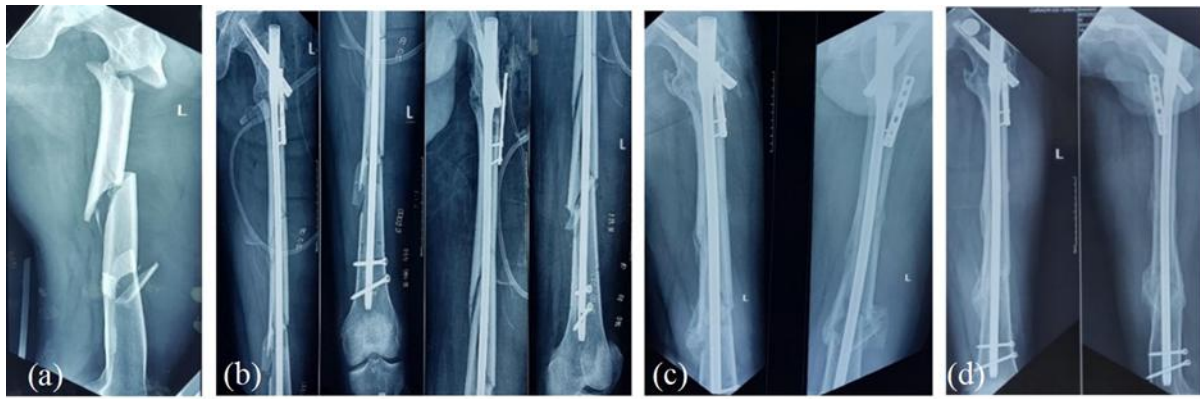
(a) Pre op, (b) immediate post op, (c) 6 month post op and (d) 1 year post op Femur Xrays (AP and Lateral view) of a participant who had delayed union
